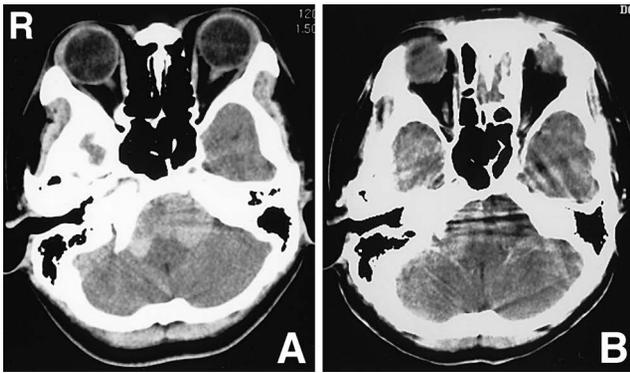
Computed tomography scans showing a slightly high density mass ventral to the lower brain stem (A) with no definite enhancement of the rim of the tumor (B).
